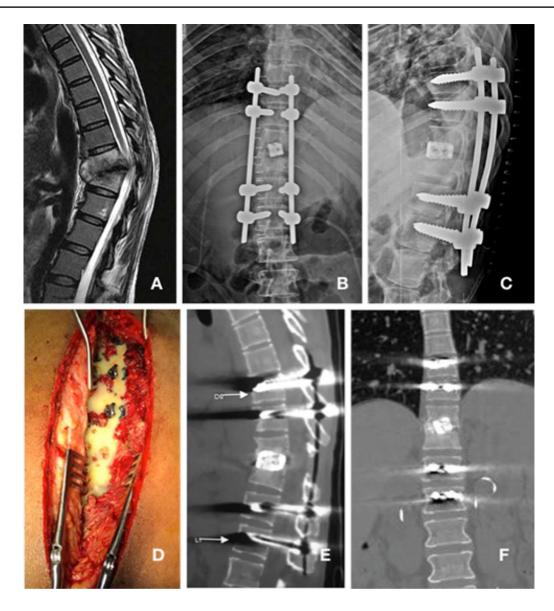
Sagittal T2W MRI (a) showing destruction of T10–T11 vertebrae with intervening disk and kyphosis with paravertebral and epidural abscess compressing the spinal cord. Immediate postoperative AP (b) and lateral radiograph (c) after posterior stabilization and fusion with interbody cage following limited debridement between
